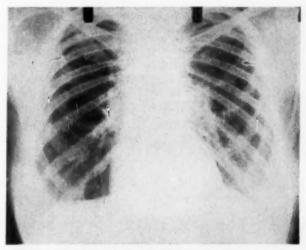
Roentgenogram of chest made June 13, 1949, showing changes indicative of sarcoid.
